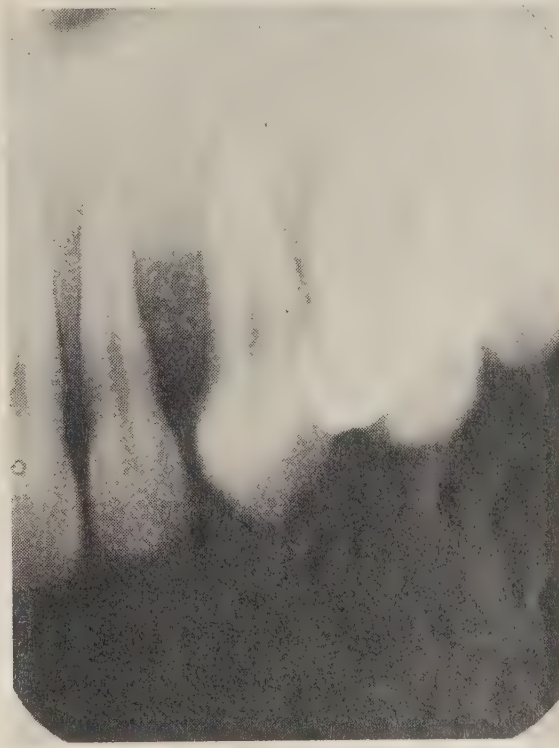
Periapical radiographs of upper jaw before parathyroidectomy. Note woolly appearance of the trabecular bone and loss of lamina dura.
